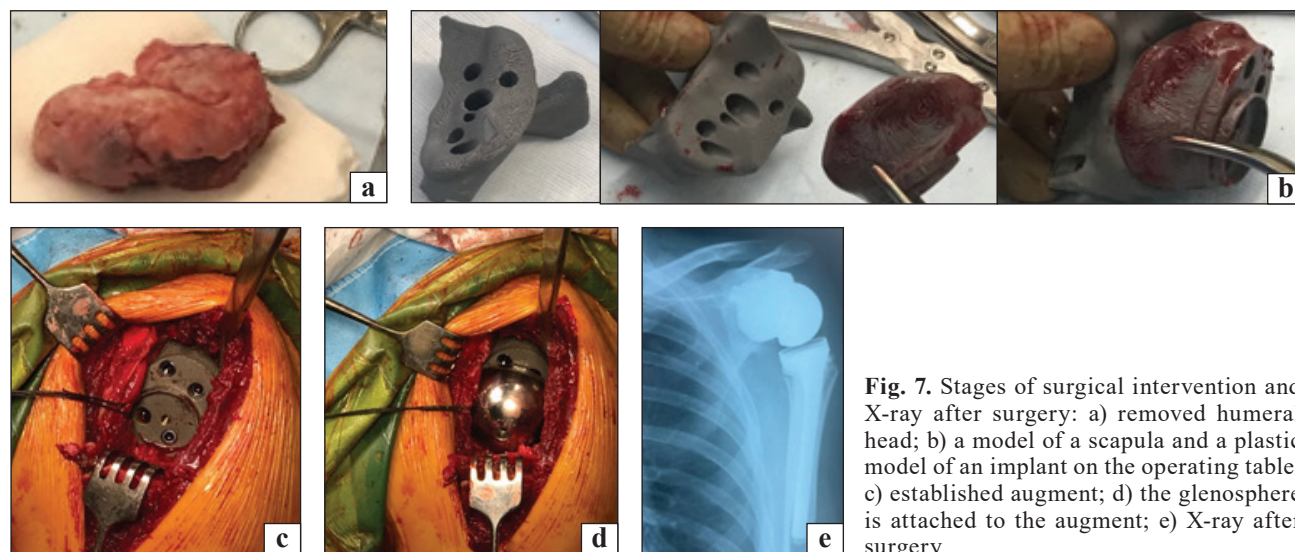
Stages of surgical intervention and X-ray after surgery: a) removed humeral head; b) a model of a scapula and a plastic model of an implant on the operating table; c) established augment; d) the glenosphere is attached to the augment; e) X-ray after surgery
